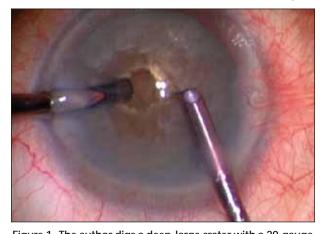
The author digs a deep, large crater with a 20-gauge sleeveless phaco tip. At this stage (mode 1), the aspiration flow rate and pressure are set low, and the hard section of the nucleus is emulsified without the phaco tip's being completely occluded. Incomplete occlusion prevents thermal burn, despite the high ultrasound power setting.
